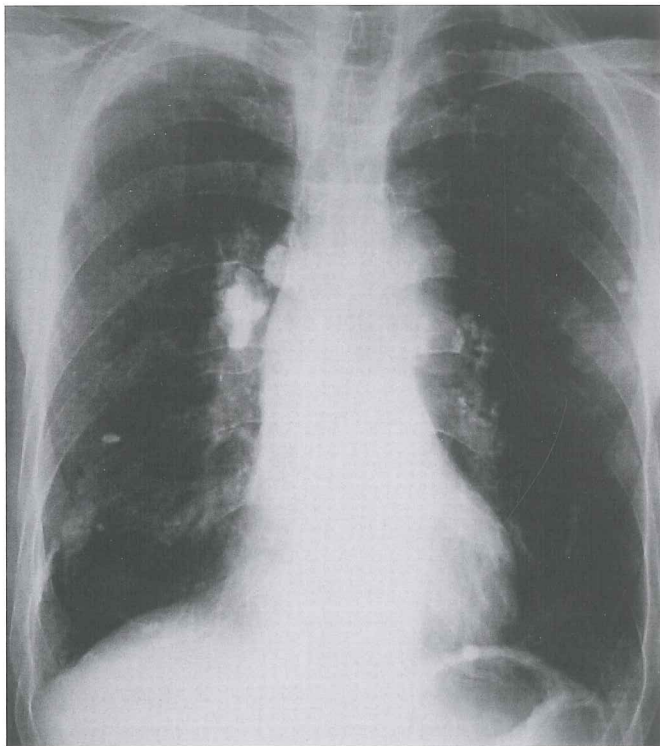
Initial chest X-ray of the patient with synchronous bladder and lung primary cancers shows widespread intrathoracic calcifications and right apical scarring. A peripheral nodule can be seen on the left middle zone (arrow).
